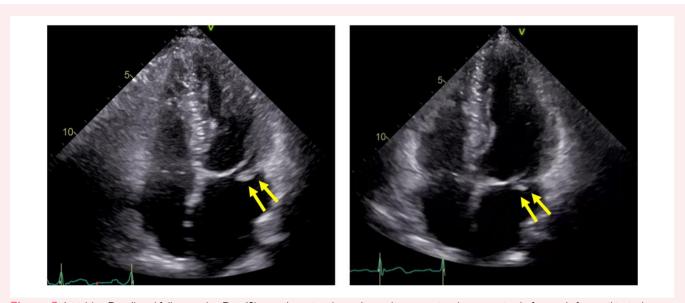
Initial (on Day 4) and follow-up (on Day 42) transthoracic echocardiography comparing the vegetation before and after antibiotic therapy.
